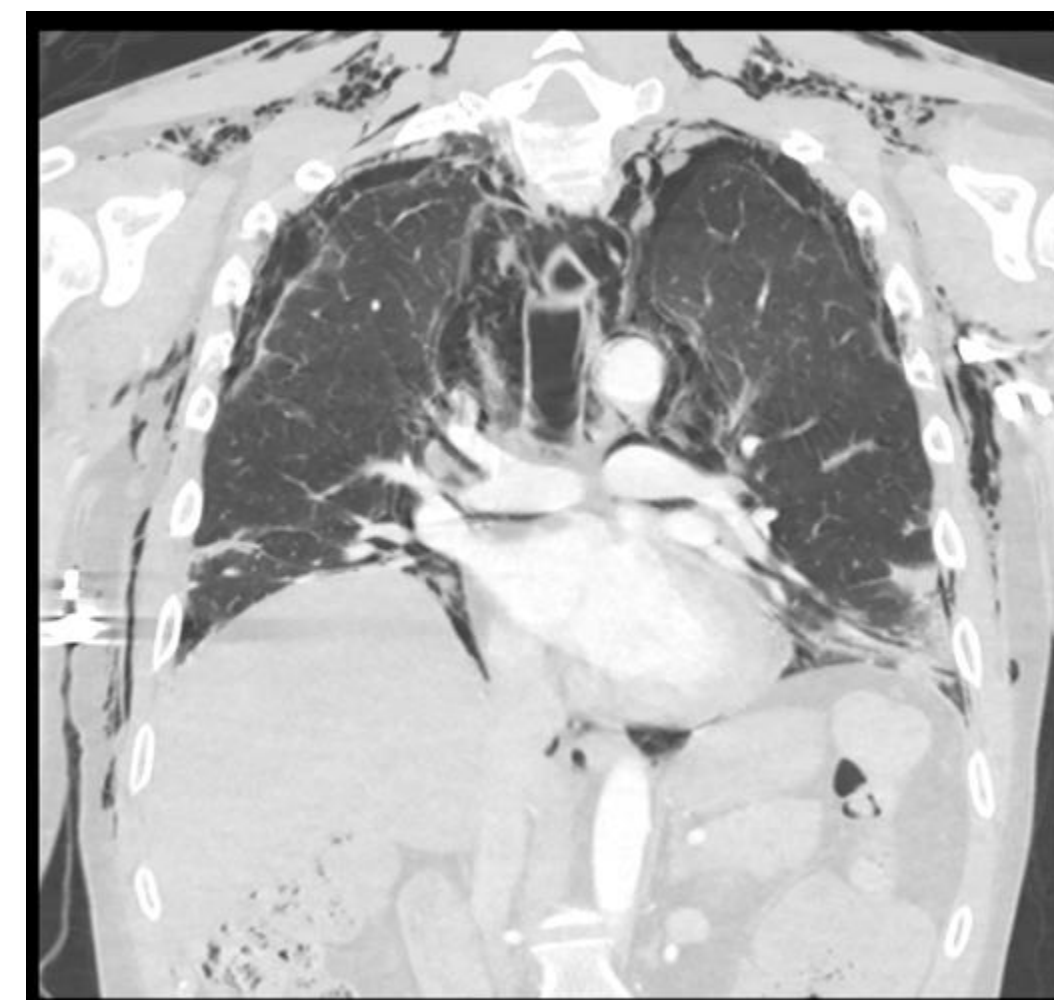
Repeat CT imaging was significant for developing significant and persistent subcutaneous emphysema, with air migrating along the broncho-vascular bundles around both hila, with air tracking into the mediastinum. Note the peripheral air bronchograms down the LLL.
